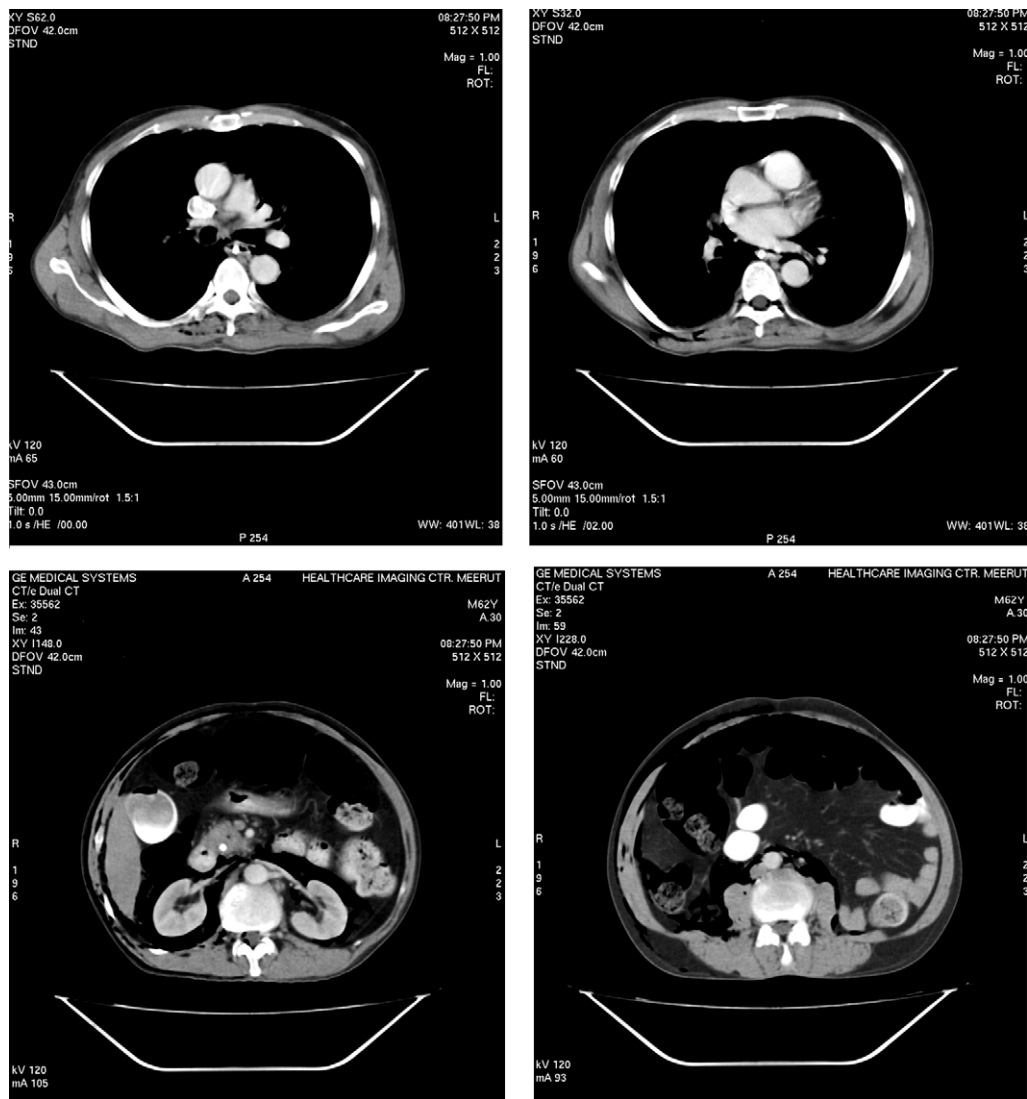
Contrast enhanced computerized tomography scans showing epidural pneumorrhachis in thoracic and sacral spinal cord. The presence of air in the subcutaneous space is visible along the body wall. The abdominal CT scans also show retroperitoneum.
